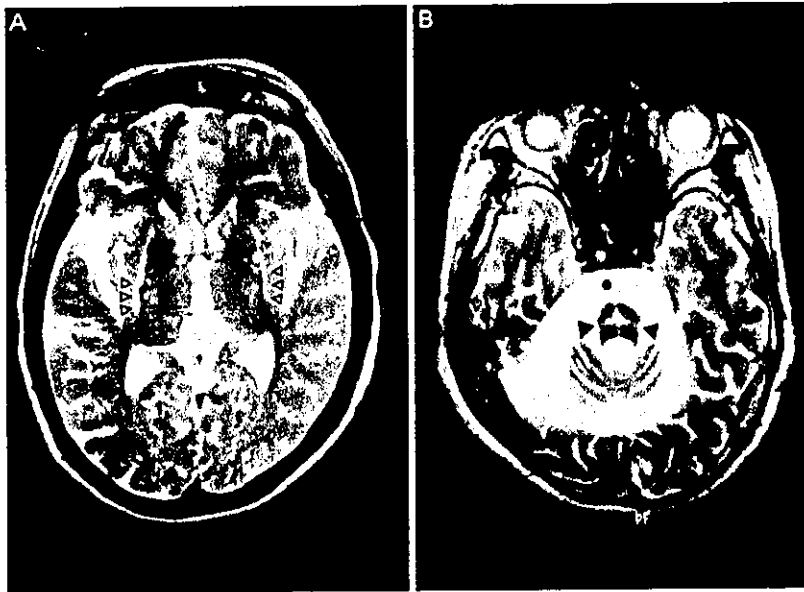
MRI signal abnormalities in patients with multiple system atrophy. (A) Hyperintense putaminal rim on T<sub>2</sub>-weighted images [1.5 T; 4000 ms repetition time (TR), 120 ms echo time (TE)] in the axial plane (arrowheads). (B) Signal change in the pons on T<sub>2</sub>-weighted images (1.5 T; TR, 4000 ms; TE, 120 ms) in the axial plane (arrowheads).
